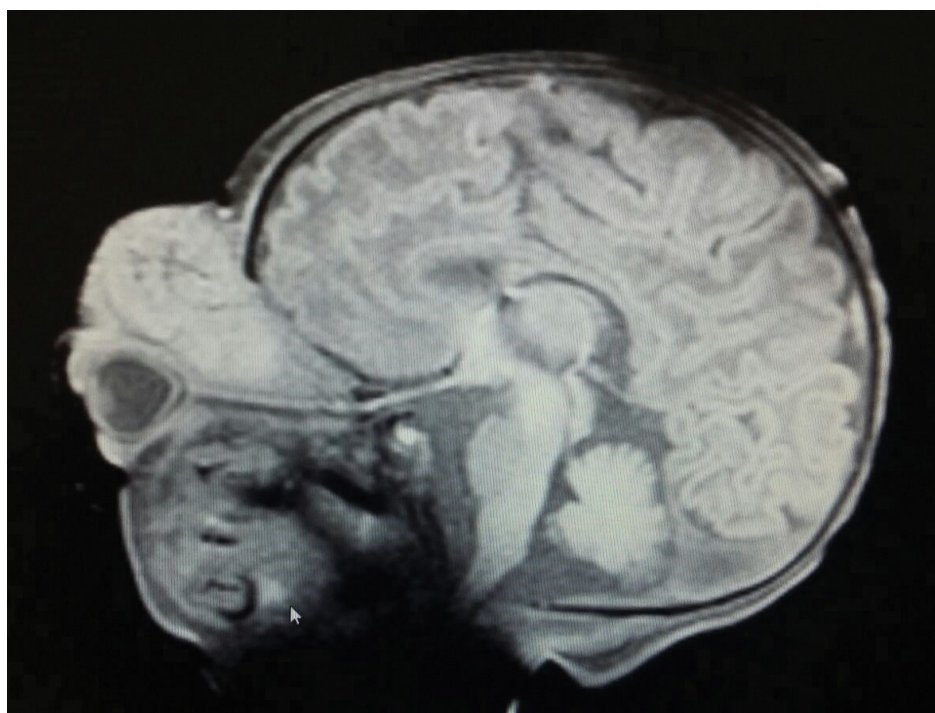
MRI image showing an intra-orbital mass causing proptosis and stretching of the optic nerve
